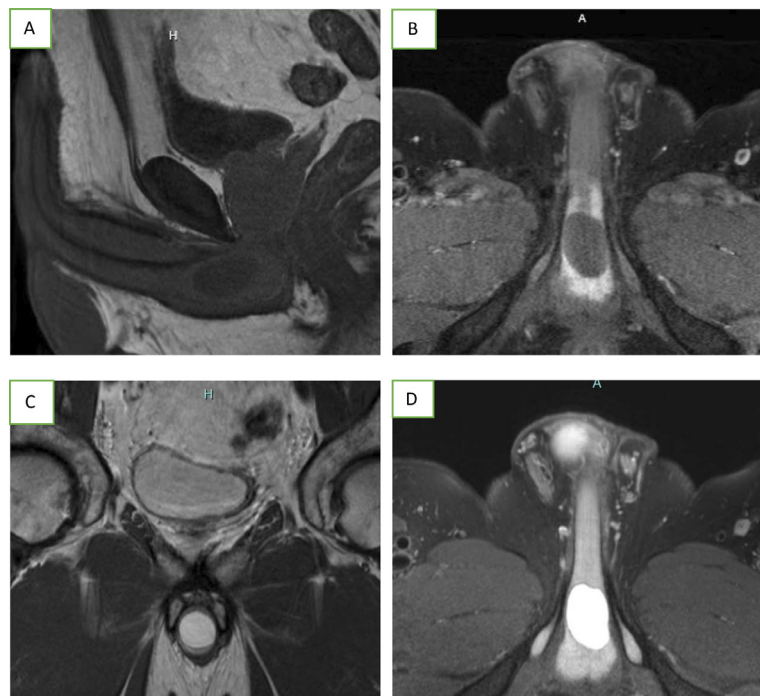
MRI Images of the corpus spongiosum cyst. (A) Sagittal T1-weighted MRI with the cyst visible inferior to the urethra. (B) Axial T1-weighted MRI presenting the axial diameter of the cyst. (C) Coronal proton density MRI demonstrating the coronal diameter of the cyst. (D) Axial T1-weighted MRI postgadolinium contrast image demonstrating the continued homogeneity of the cyst post contrast administration.
